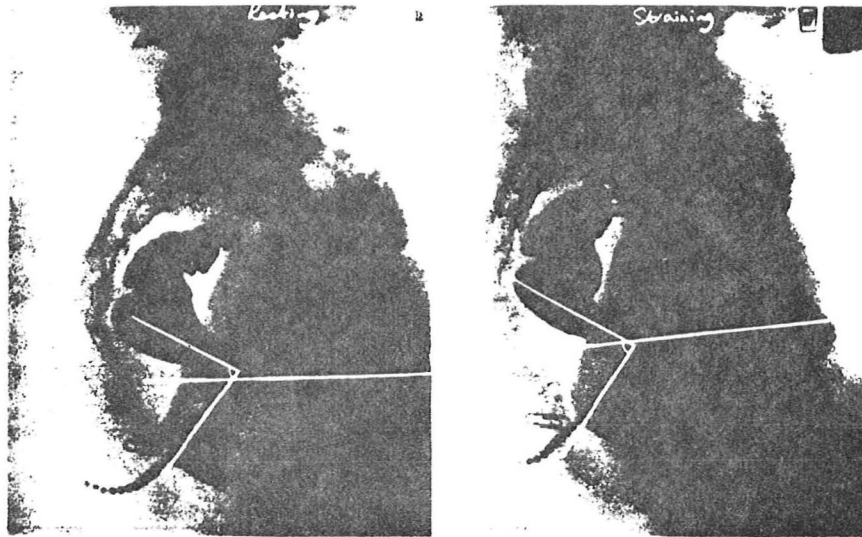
Lateral Radiographs of the Pelvis in a Normal Individual at rest (left) and while straining (right). The rectoanal angle and pubococcygeal line are indicated (From Bartolo et al, 1983b).
